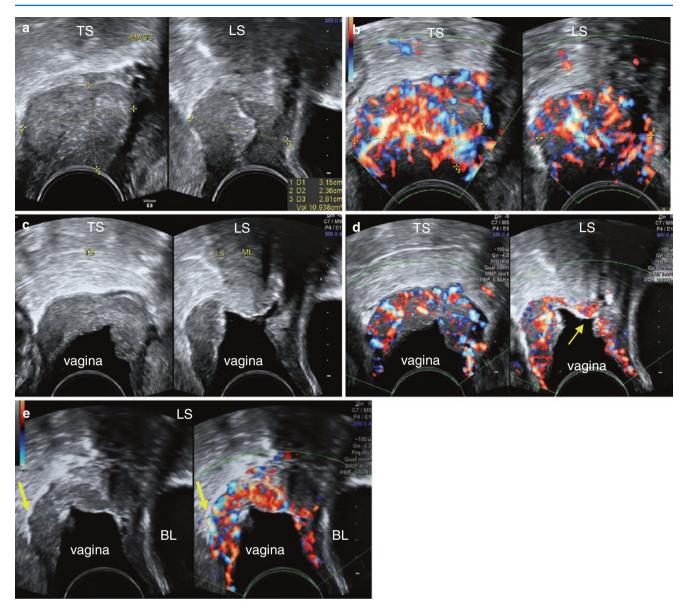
58-year-old lady referred with a neoplastic mass in the vagina. (a) Hypoechoic slightly heterogeneous mass seen in upper vagina. (b) Increased vascularity noted in the mass. (c–e) On GSV, vaginal walls are seen apart with a clear delineation of the tumour margins, the lower cervix and the external os. In (d), the vascularity helps assess the extension of tumour into the cervical lips around the external os (*arrow*). This makes primarily a cervical cancer (and not vaginal). (e) On careful observation, the irregularity of the white external fascia of the posterior vaginal wall on greyscale and Doppler suggests early paravaginal extension (*arrows*). *HPE*: squamous cell carcinoma
